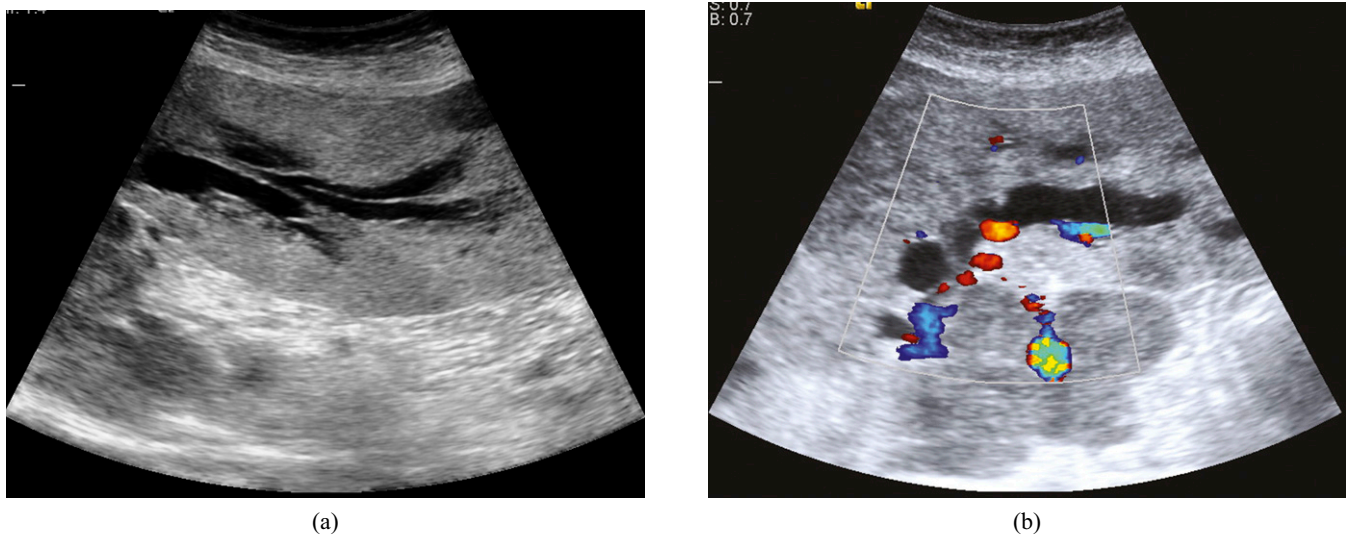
(a,b) Ultrasound scan images through the liver in a female patient with jaundice showing dilated intrahepatic ducts. Colour Doppler can help distinguish dilated duct from adjacent vessel (b). This was secondary to a carcinoma in the head of the pancreas.
